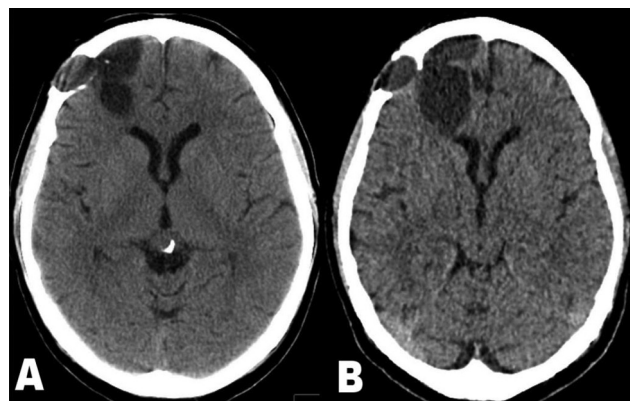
(A) Plain computed tomography (CT) of the head from 2008 showing a 4 × 3 cm trilobed cystic structure occupying the right frontal lobe with associated frontal bone erosion suggestive of a long-standing pathology. (B) Plain CT of the head from 2020 showing the marginally increased 5.4 × 4.2 cm hypointense cystic lesion suggestive of a benign etiology.
